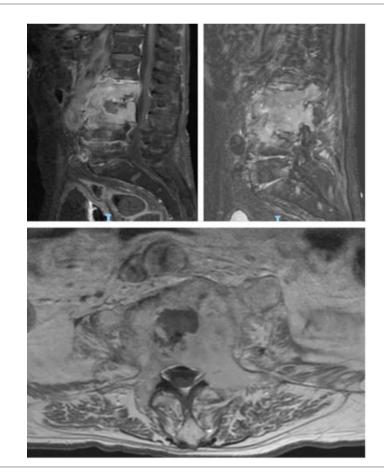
First MRI scan of the lumbar spine performed after admission at our hospital. The MRI scan confirms the presence of an osteolytic lesion at L2-L3 level with extension to the posterior elements and pre-vertebral tissues. A repeat CT guided biopsy was performed but again was not conclusive.
